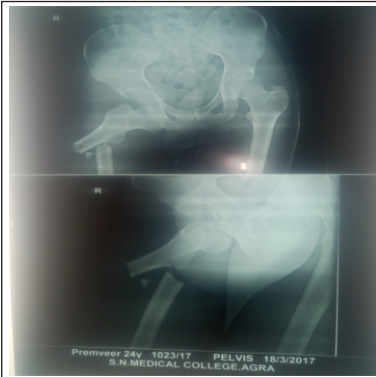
Preoperative radiograph of patient
